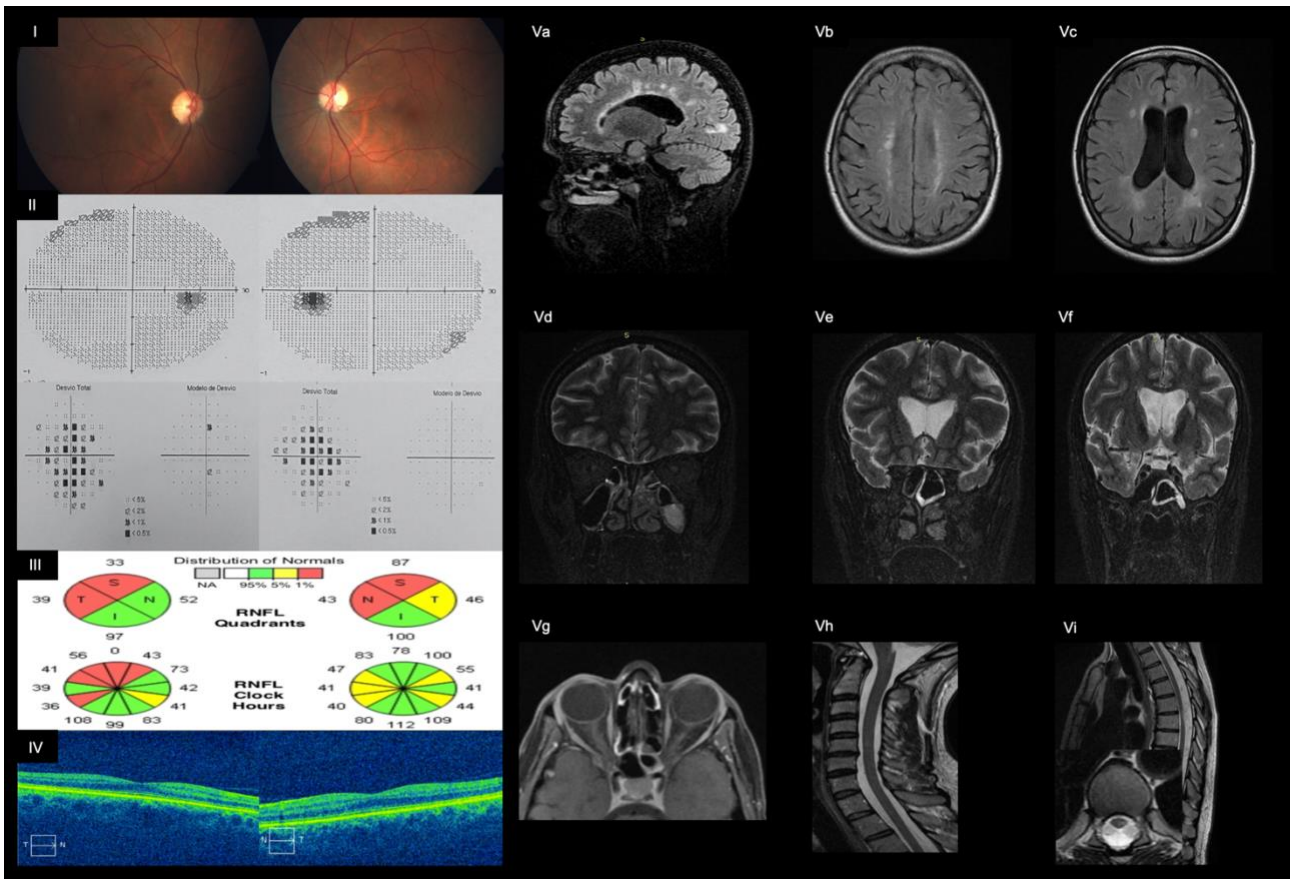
Summary of the case history (# Patient number 7) - Woman, 49 years, female, white. The visual index event occurred with 32 years old (2001) and was characterized by acute visual dysfunction at right eye and complete recovery. Seven years later occurred the Transverse Myelitis Index event characterized by acute paresthesia and mild sensorial objective deficit in inferior limbs with upper limit in T10 associated with acute T10 spinal cord lesion with contrast enhancement. Four other acute and reversible events of right ON (2-2002;1-2006;1-2012; – see in figure 1). The patient refused DMF for MS. At the last follow up after 17 years of disease the visual acuity with best correction was 0.1 in both eyes without other neurological deficit. (FS visual = 1, EDSS = 1) The figure 5 presents the documentation of the neurophthalmological exams: I. Retinography: Mild pale optic disc in temporal sector in both eyes; II. Automated perimetry: Diffuse defect in both eyes; III-IV. OCT: III. Average of pRNFL of 59  $\mu\text{m}$  in RE and 69  $\mu\text{m}$  in LE.; IV. Orion retina segmentation showed a mGCIPL of 52  $\mu\text{m}$  in RE and 56  $\mu\text{m}$  LE; V(a-i)MRI: a. Sagittal FLAIR: images shows typical demyelinating plaques that mainly involve the periventricular white matter; b. Axial FLAIR: lesions hyperintense; c. Axial FLAIR: lesions hyperintense in periventricular white matter; d. Coronal STIR (short tau inversion recovery): the affected optic nerves shows high signal intensity; e. Coronal STIR (short tau inversion recovery): the affected optic nerves shows high signal intensity; f. Coronal STIR (short tau inversion recovery): normal chiasm; g. Axial T1 FAT SAT with contrast: no contrast enhancement in optic nerves; h. Sagittal cervical cord imaged with T2: observe the multiple small focal lesions that do not exceed two vertebral segments in length; i. Sagittal and axial thoracic cord imaged with T2: the lesions occupy lateral white matter columns and do not affect more than half the cross-sectional area of the cord (left).
